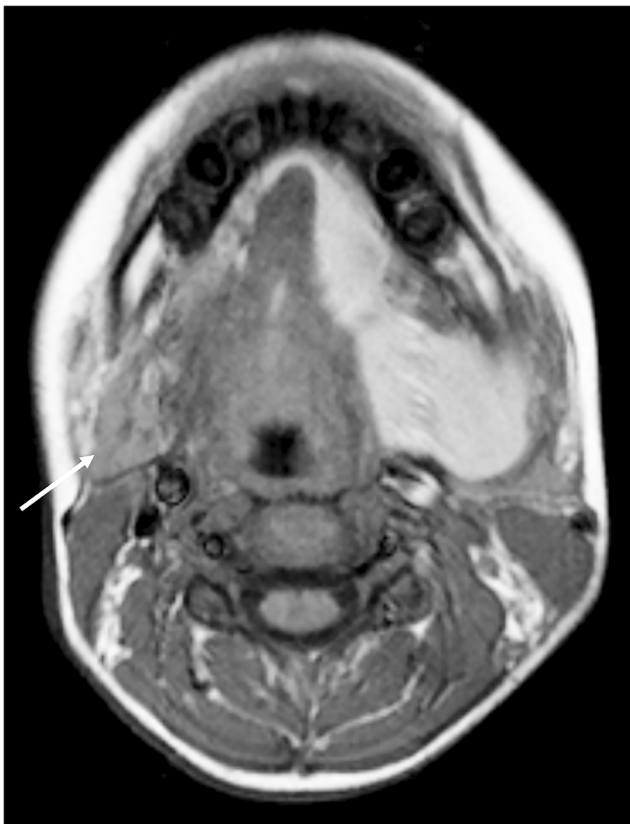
Axial T1-weighted image in a 14-year-old boy shows a left plunging ranula extending in the submandibular space. The ranula shows increased T1 signal consistent with highly proteinaceous fluid. Note the normal submandibular gland on the right (*arrow*)
